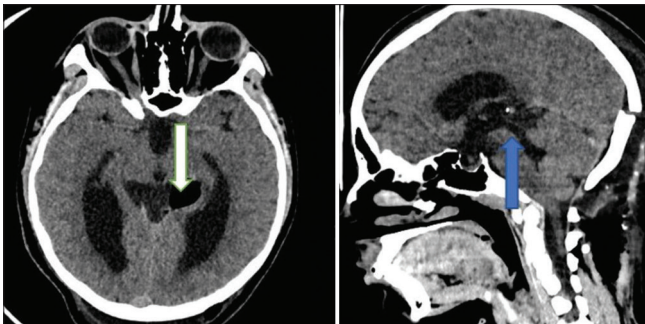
Day 1 postoperative CT showing reduced cyst size and pneumocephalus (white arrow) and restored cerebral aqueduct patency (blue arrow).
